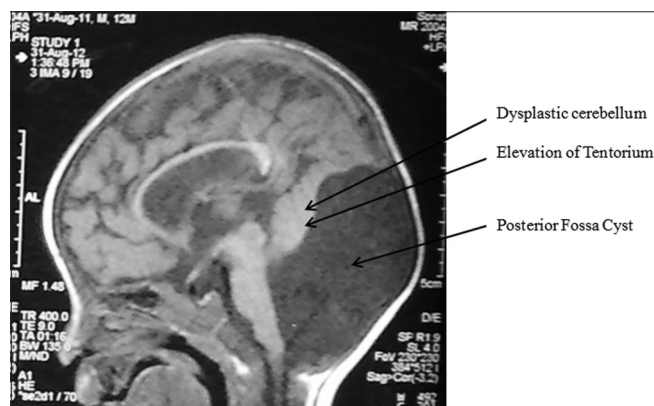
Magnetic resonance imaging brain shows enlarged posterior fossa with cystic dilatation of fourth ventricle, elevated tentorium with cerebellar hypoplasia. This image is suggestive of a possibility of aqueductal stenosis
